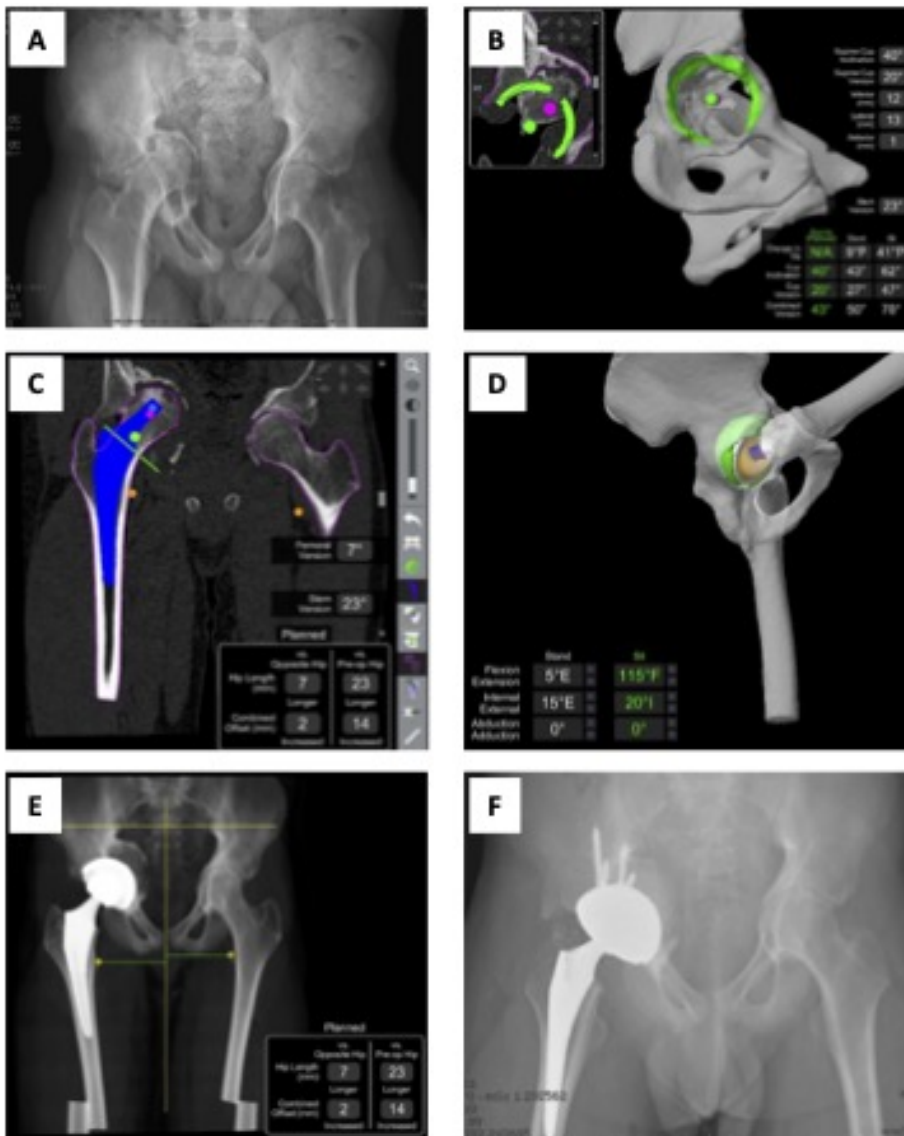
Preoperative planning with post-operative radiograph. (A) Preoperative X-ray in a 17-year-old male with DiGeorge Syndrome. (B) Acetabular implant plan with planned impaction grafting of protrusio defect. (C) Femoral implant plan. (D) Virtual range of motion with impingement at 115° flexion and 20° internal rotation. (E) Virtual anteroposterior (AP) pelvis X-ray. (F) Clinical 6-week postoperative AP pelvis X-ray.
